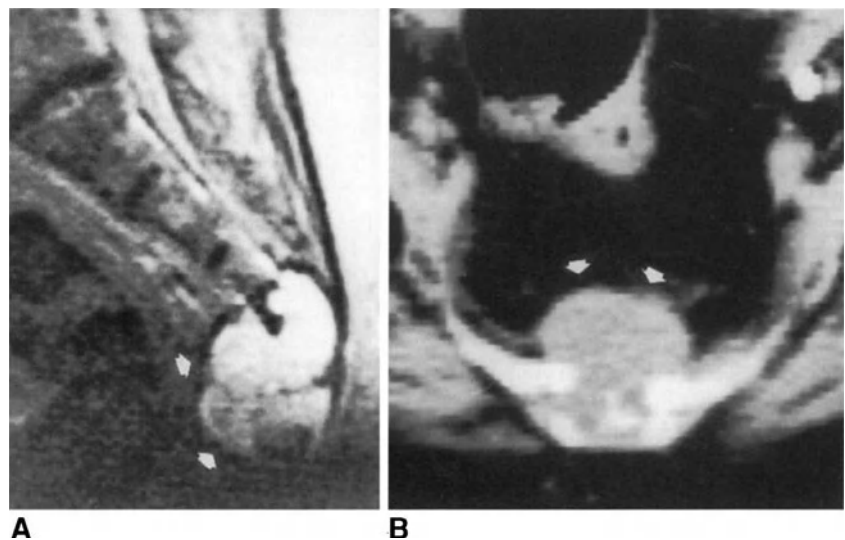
Chordoma in the sacrococcygeal region. The T2-weighted spin-echo MR image (A) shows a highly hyperintense lobulated lesion (arrows). On CT scan (B), a mass with parenchymatous density (arrows) is visible, which has eroded the anterior cortical bone of the sacrum.
